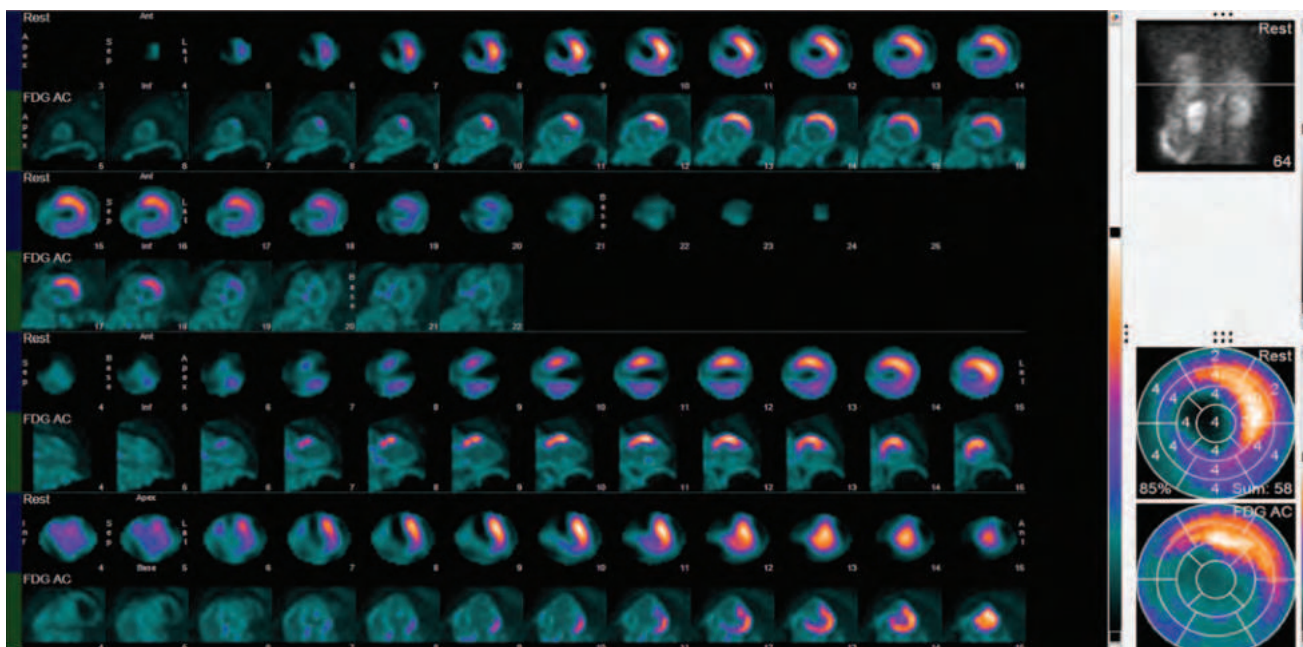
A 58 years old male having TVD on CAG, Echo: EF-28% with marked global hypokinesia. ^{18}F FDG PET: Perfusion-metabolism matched defect in triple vessel territories suggested non-viable myocardium. Rx: Not recommended for revascularization, on medication. (TVD-Triple vessel disease)
